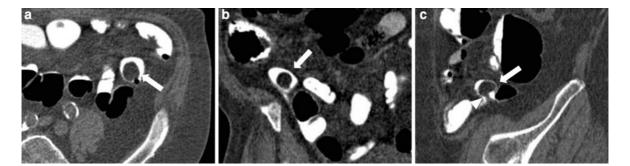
Axial (a), coronal (b) and sagittal (c) CT image showing, within the last small bowel loop, a well-circumscribed ovoid mass with fat attenuation (*arrow*) and short stalk (*arrowhead*), suggestive for lipoma
